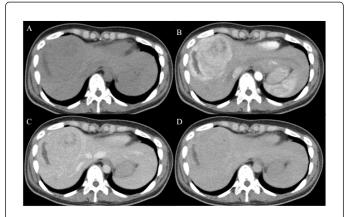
(A) plain CT image. (B) contrast CT at the early arterial phase, (C) contrast CT at the late arterial phase and (D) contrast CT at equivalent phase. These revealed that tumor showed at intense enhancement in the arterial phase and a contrast wash-out in late venous contrast phase.
